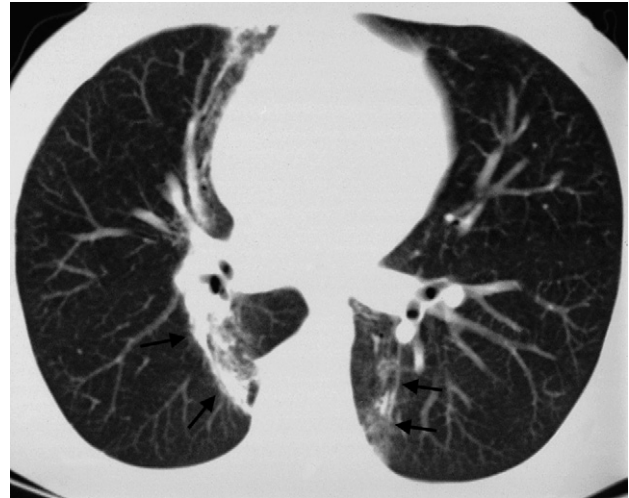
CT in a patient treated with radiation therapy for lymphoma. Note the linear fibrosis (arrows) in the lungs on either side of the mediastinum.
